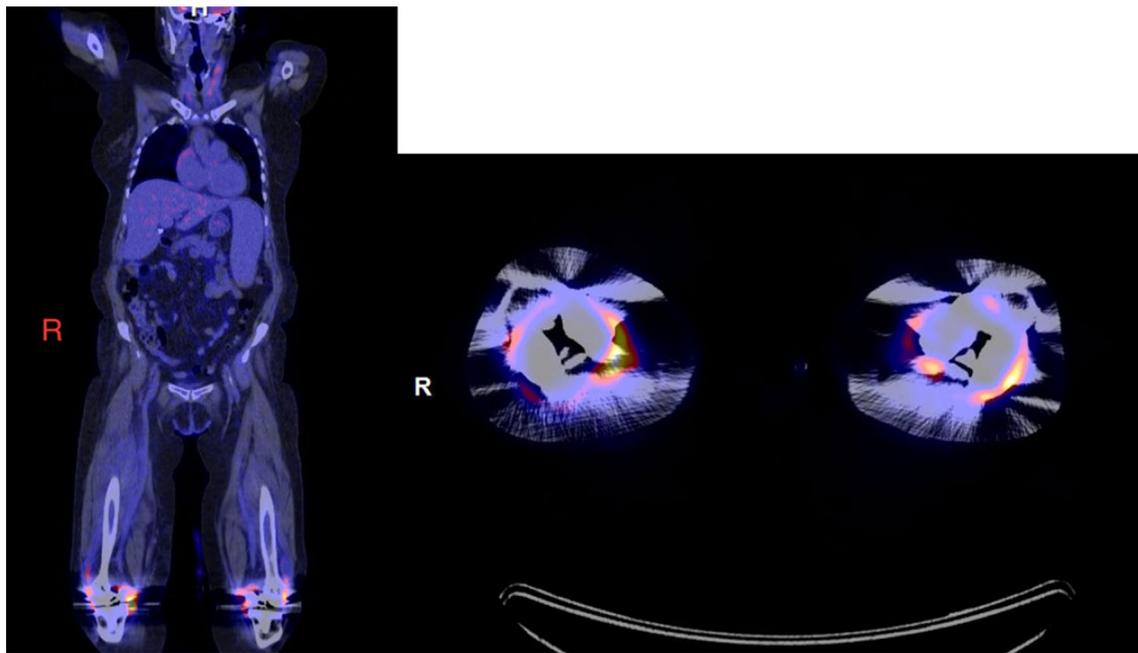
FDG PET-CT. *Left* coronal view, *right* axial view
